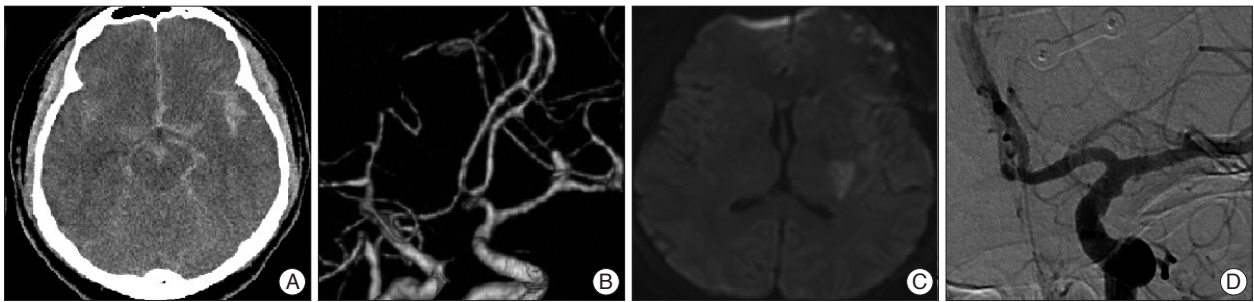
A : Initial brain computed tomography (CT) showing subarachnoid hemorrhage in basal cistern and left sylvian fissure. B : A 64-detector 3-dimensional CT angiogram showing a saccular aneurysm on the left M1 portion of middle cerebral artery. There is no abnormal finding in anterior communicating artery. C : 1 day after clipping, diffusion weighted magnetic resonance image showing ischemic change of left posterior limb of internal capsule. D : 1 day after clipping, the trans-femoral catheter angiography showing no abnormality in anterior communicating artery except mild vasospasm in peripheral arteries (not shown).
